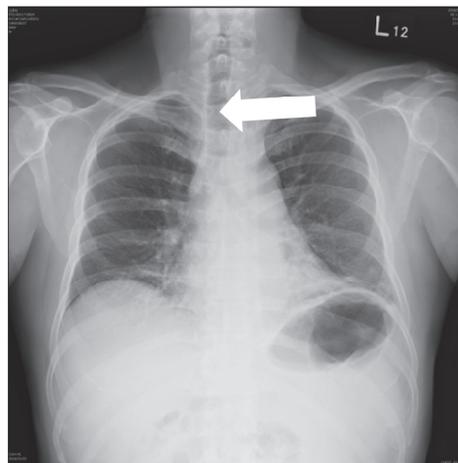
X-ray imaging showing air density on the left side of the para-tracheal space (arrow).
